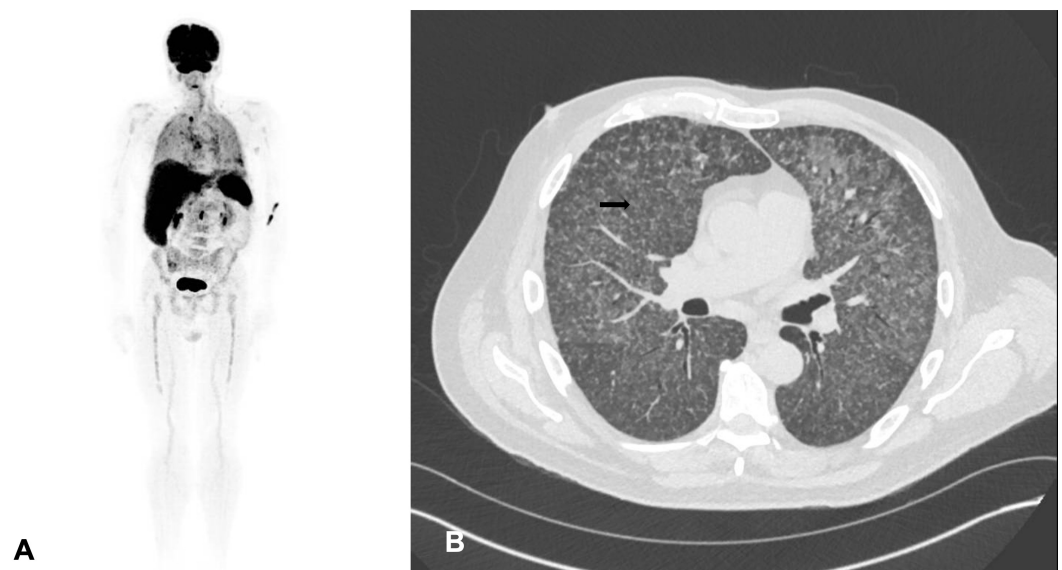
Imaging findings suggestive of disseminated tuberculosis. ^{18}F -fluorodeoxyglucose (FDG) uptake scan demonstrating avid hepatic, splenic, pulmonary, and bone marrow uptake (A); subsequent high-resolution computed tomography of the chest demonstrating miliary pattern bilaterally (B-arrow).
